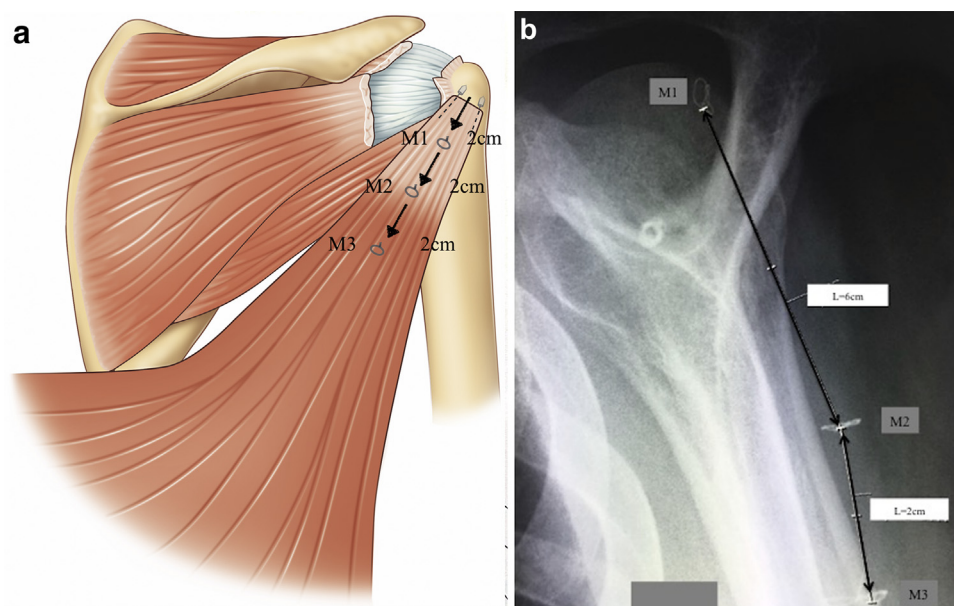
(a) After the tenotomy, the tendon is flat and reinserted onto the footprint of the supraspinatus. Three metallic markers are placed into the tendon every 2 cm from the tip. (b) Ruptured tendon transfer: radiograph 3 months postoperatively. The distance between the metallic markers M2 and M3 is the same as it was immediately postoperatively, but the distance between M1 and M3 increased from 2 cm to 6 cm. This is a proximal rupture of the tendon.
